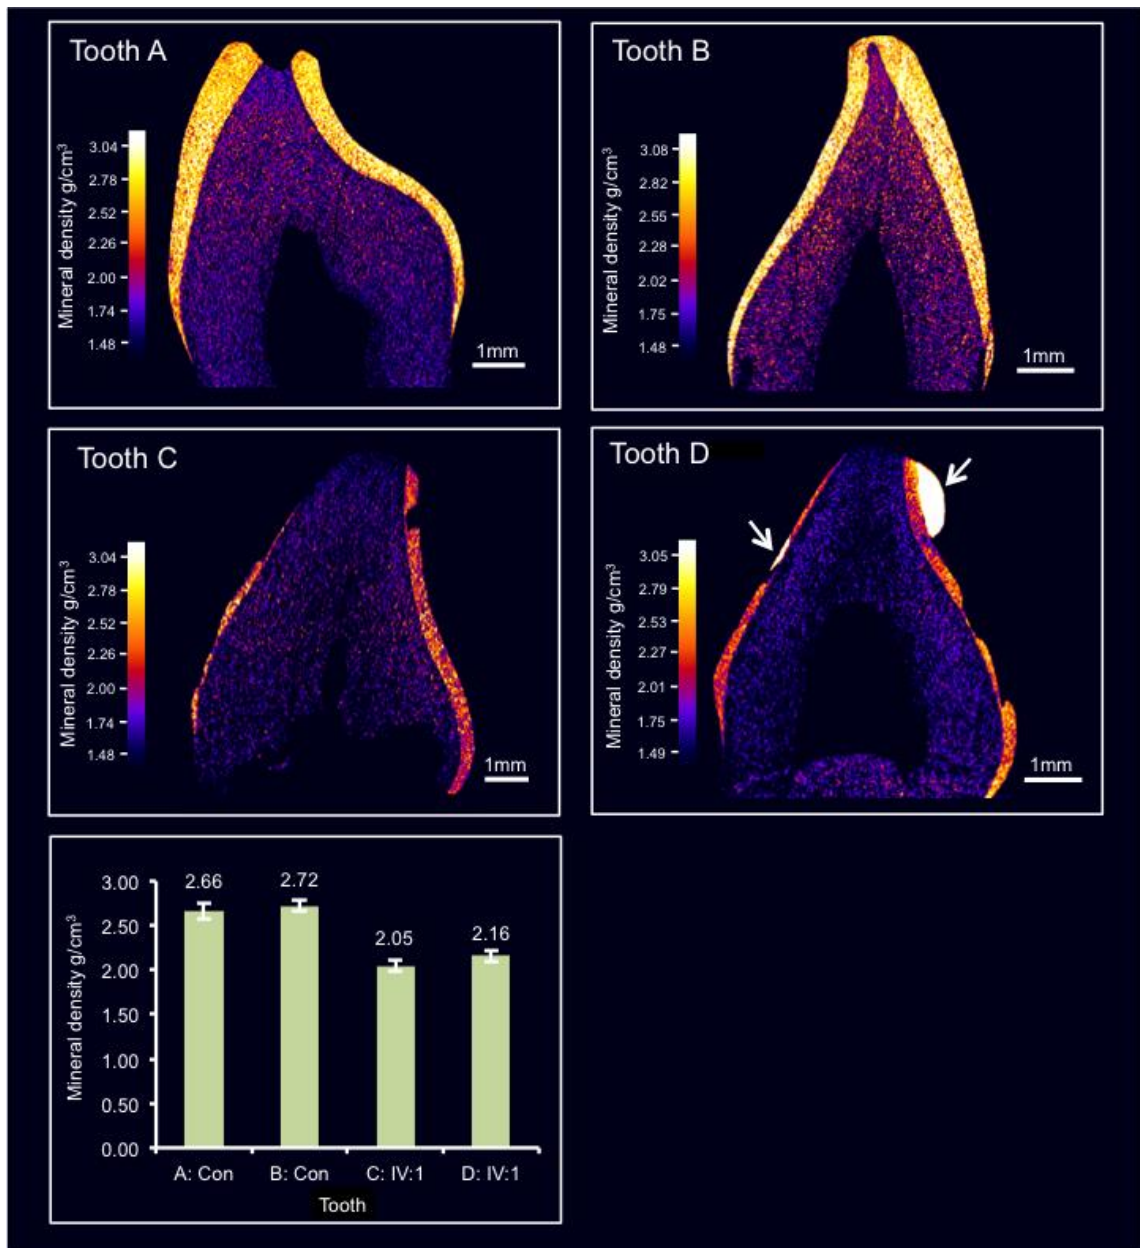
High resolution X-ray CT analysis of exfoliated teeth from two control individuals and from individual IV:1.
